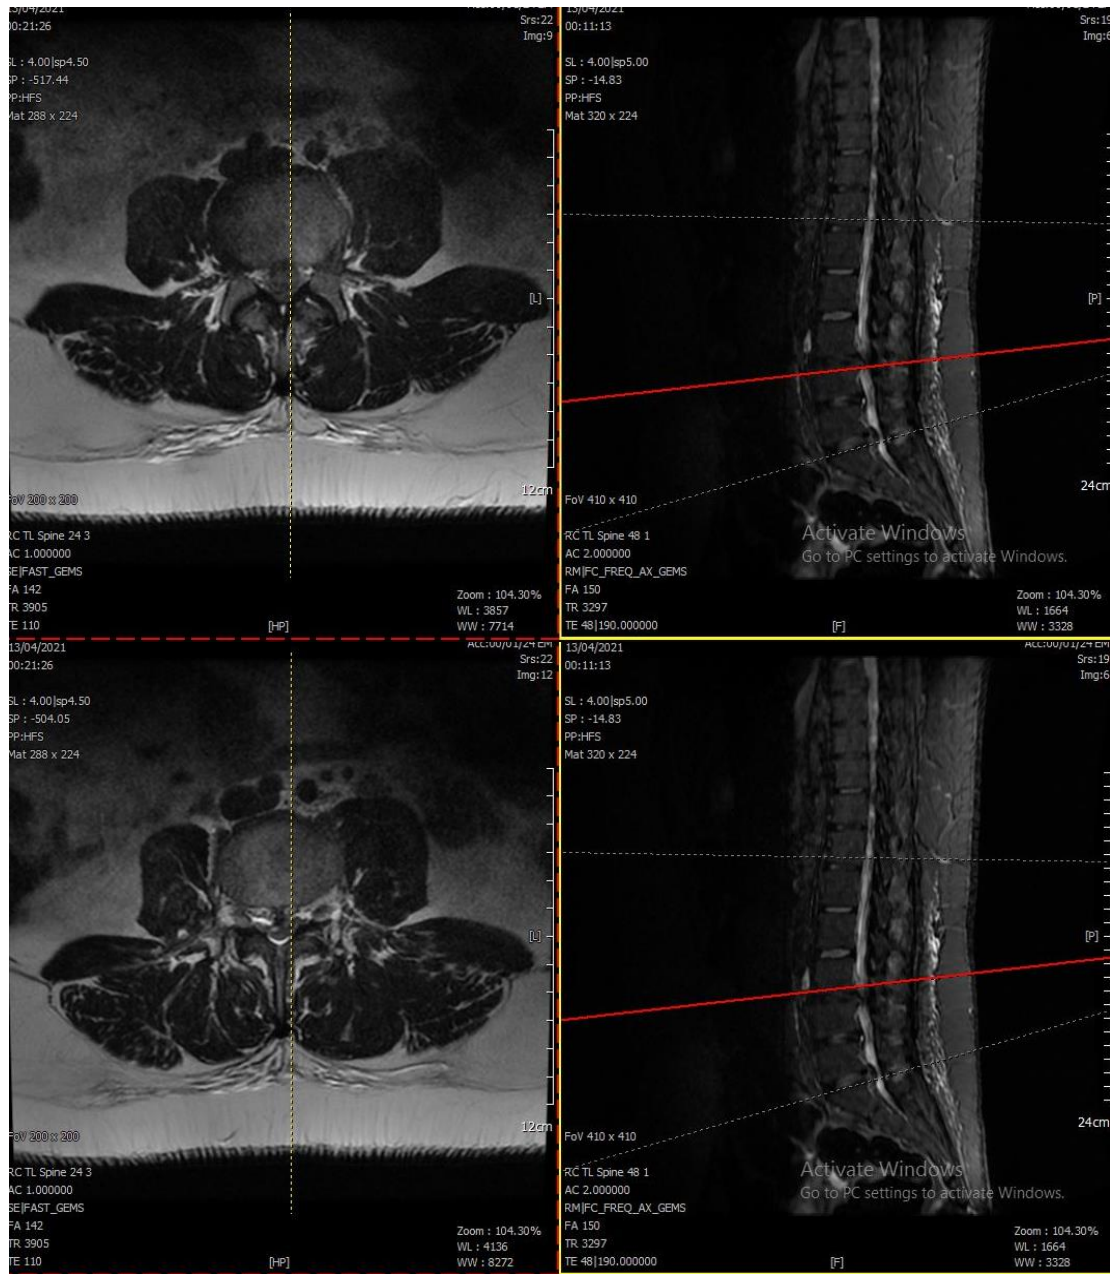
Lumbar magnetic resonance imaging (MRI) in axial and sagittal view showed L3-L4 central disc herniation that blocked the cauda equina.
